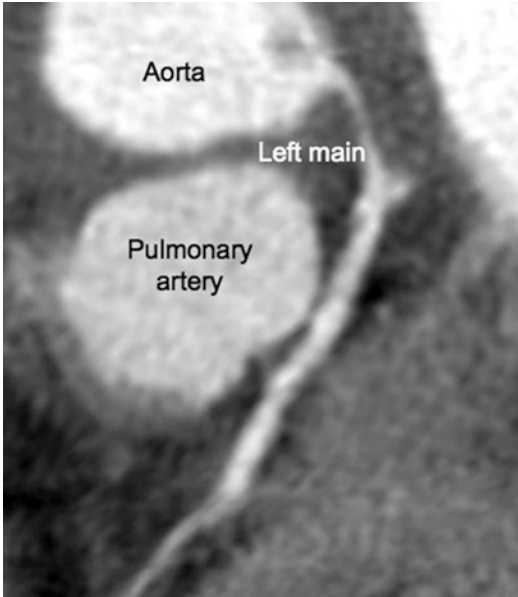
Chest computed tomography showing a long obstruction of the left main coronary artery due to extrinsic compression
